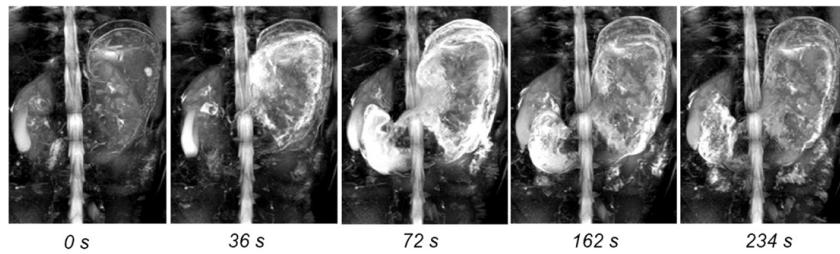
Visualization of the Magenstrasse by use of maximum intensity projections (MIP) generated by MRI. In the underlying T2-weighted MR images it can be observed that water (bright areas) is flowing around the food mass in both, coronary and transversal view [30]. Copyright (2014) American Chemical Society.
